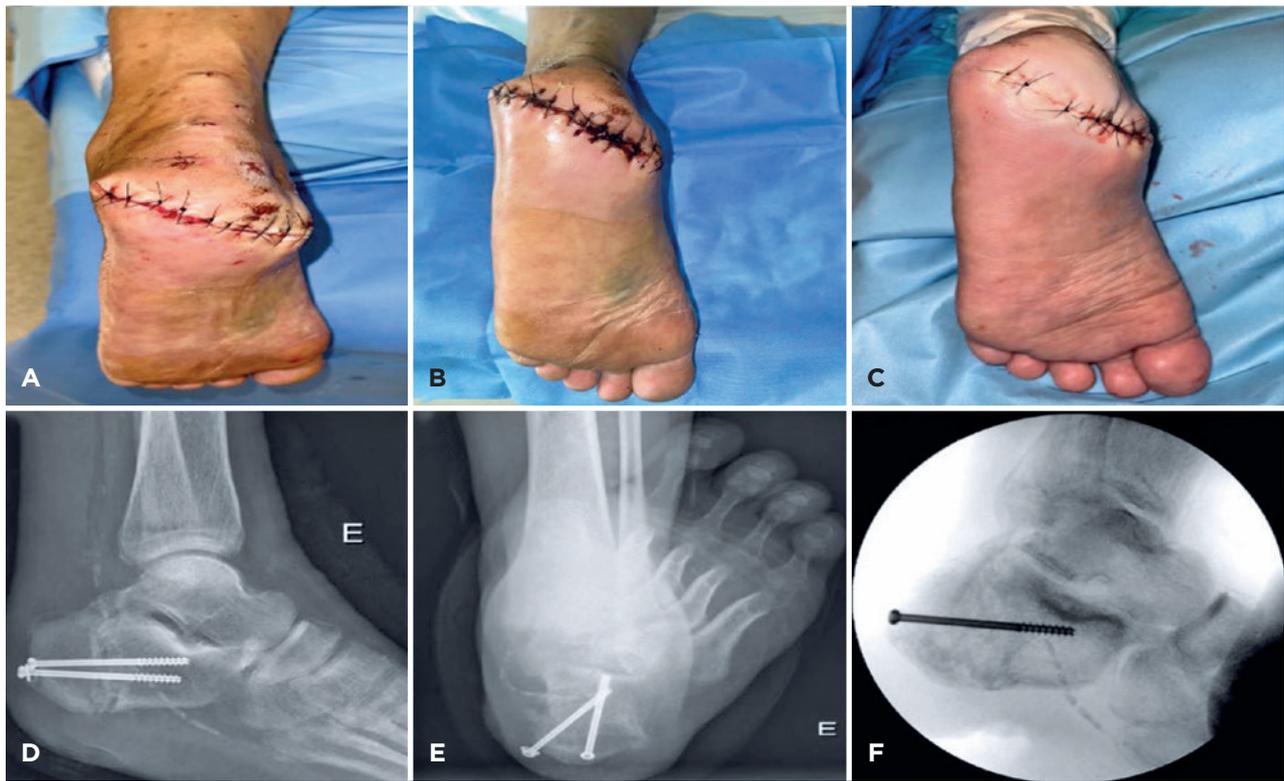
(A) Suture in the immediate postoperative period. (B) One week surgical wound. (C) Suture after revision wound and removal of a cannulated screw after six weeks. (D) Profile calcaneal radiography and (E) Axial calcaneal radiography, observed loosening of one cannulated screw. (F) Intraoperative control of removal of one screw.
